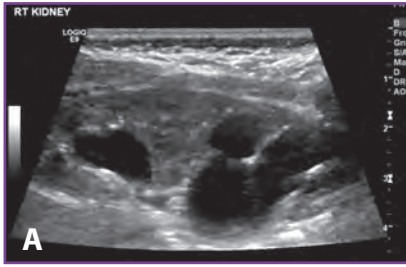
A, Ultrasonography shows a duplicated right kidney with dilation of the upper pole and lower pole renal pelvis. B, Voiding cystourethrography shows vesicoureteral reflux into both moieties of a right duplex system.
